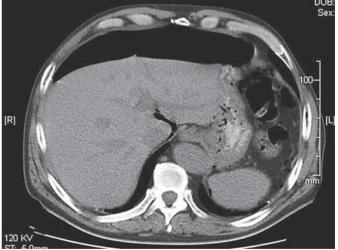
Abdominal contrast-enhanced computed tomography showing pneumoperitoneum and many distended loops of the small bowel (axial view).
